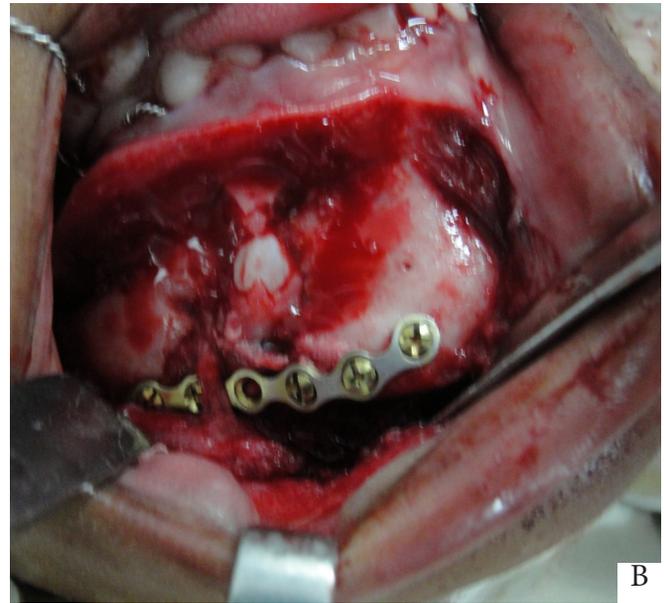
A&B Panoramic Radiograph Showing Right Parasymphysis Fracture. Open Reduction and Internal Fixation of Right Parasymphysis Fracture
